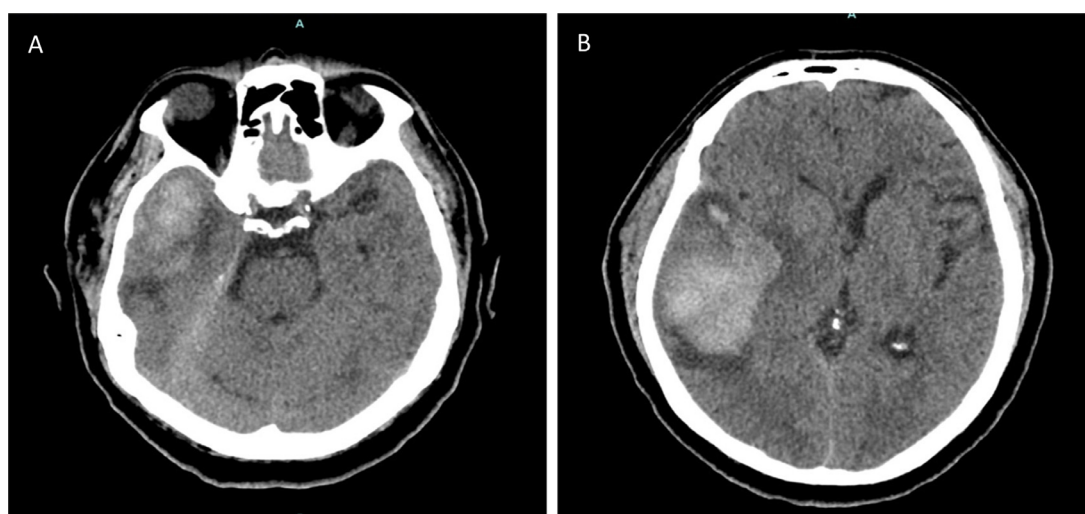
Second non-contrast CT of the head showing interval development of a new right temporal IPH (A) and impact on the right ventricles (B).
